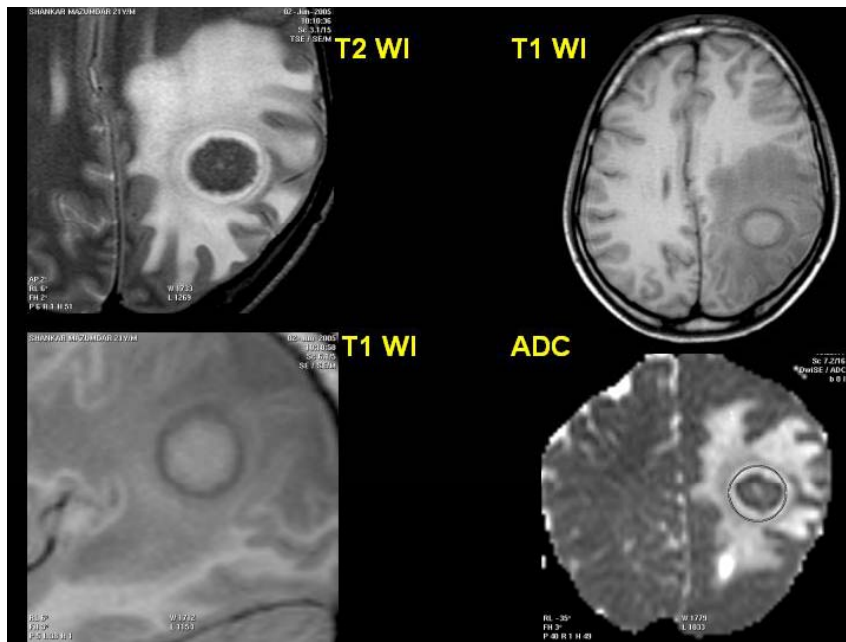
MRI shows, a circumscribed nodular, peripheral enhancing lesion with central hypointense area and hyperintense rim on T2 WI in the left parietal lobe ; ? Granuloma. ? Neoplasm
